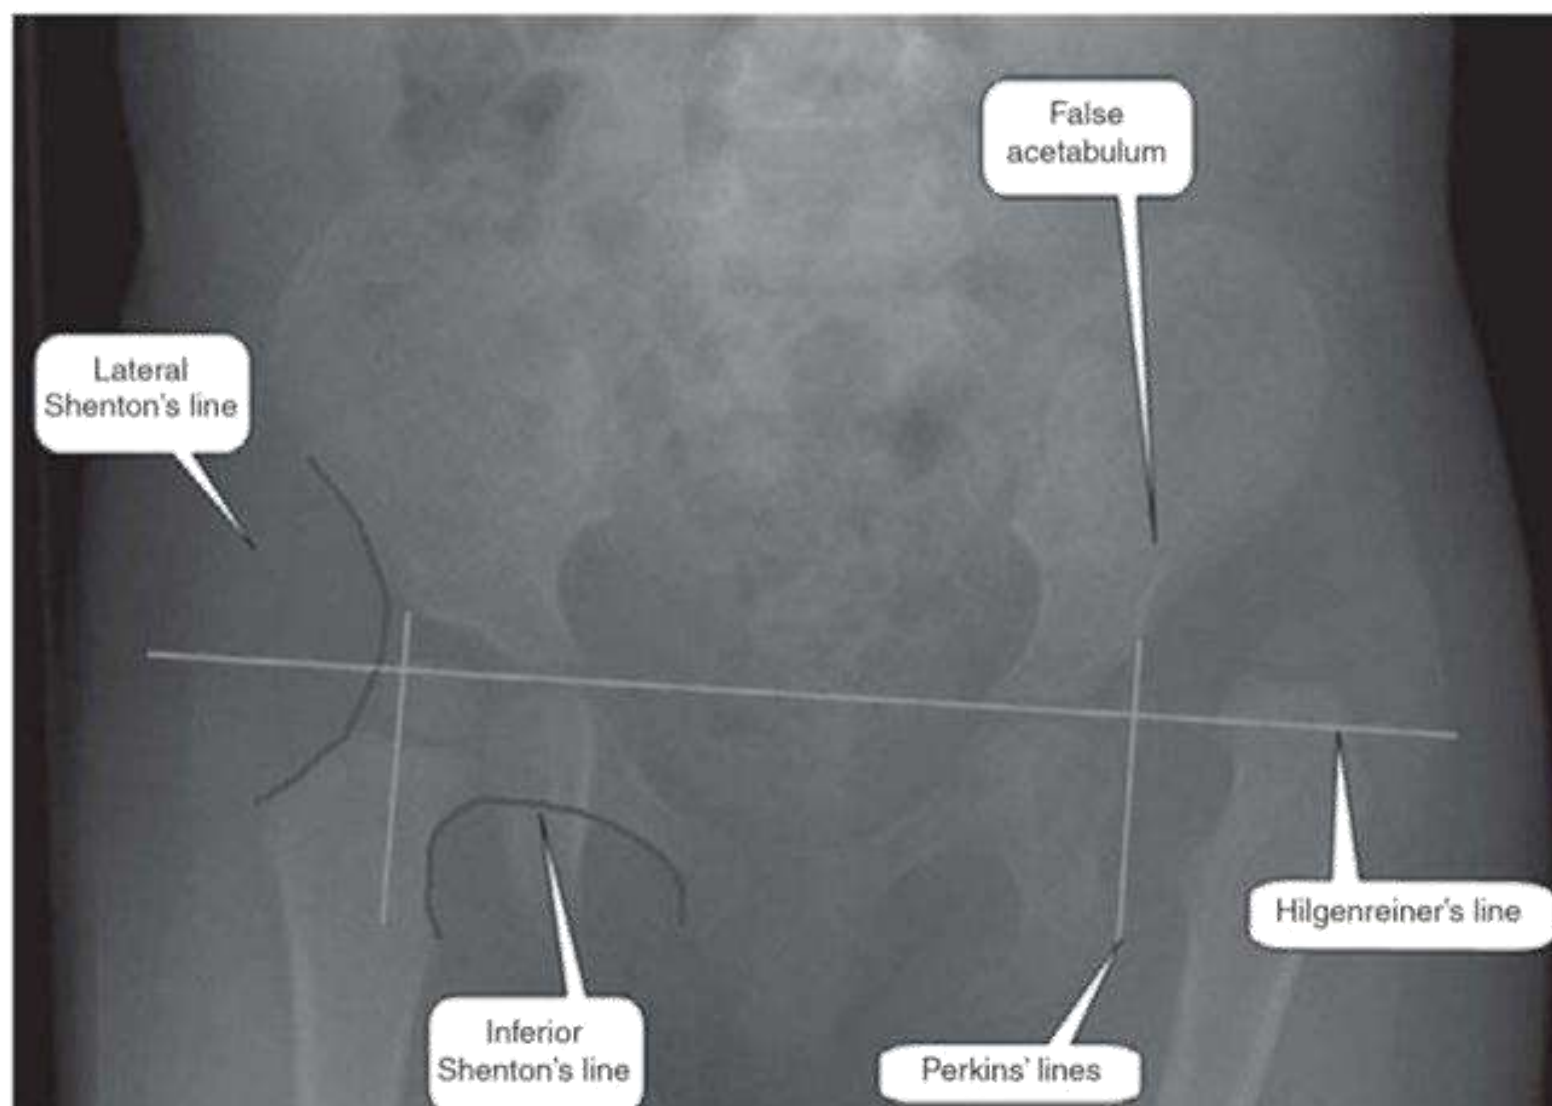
Pelvis X-ray of the hip of a 19-month-old child.
